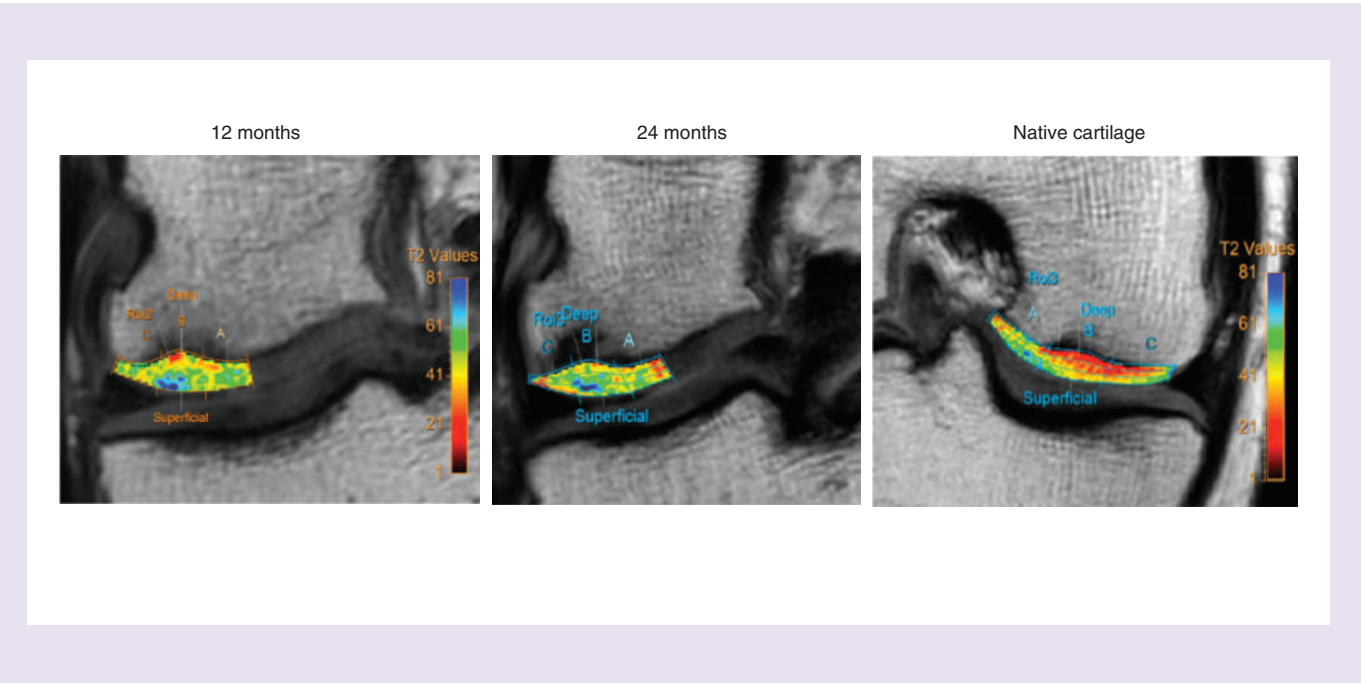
Example of sequential magnetic resonance imaging T2 mapping of the area of cartilage regeneration at 12 and 24 months. Formal T2 mapping was done over a number of slices to include the entire lesion and area of regeneration. This analysis indicated improved maturation over time with comparable T2 values to native cartilage.
